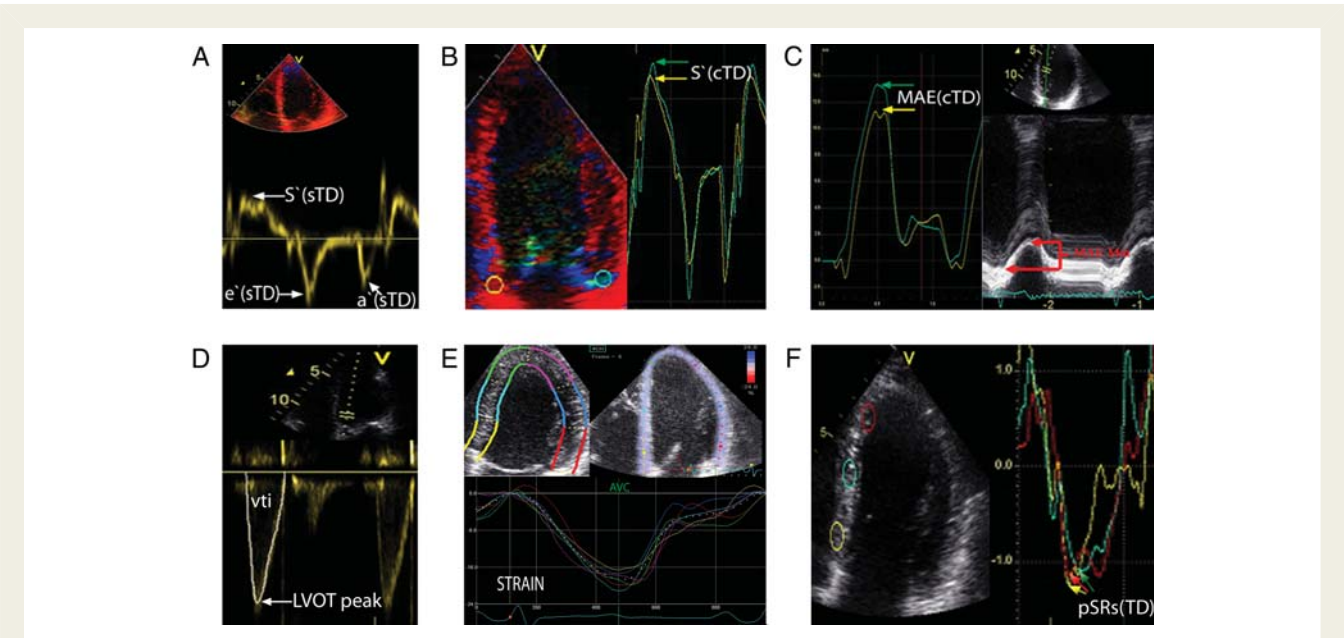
Representative measurements of left ventricular systolic performance obtained by different methods. (A) Spectral tissue Doppler (sTD)-derived septal mitral annulus velocities. Peak systolic velocity $S'(sTD)$, early diastolic velocity $e'(sTD)$, and late diastolic velocity $a'(sTD)$ measured at the maximum of the Doppler spectrum with a low gain setting. (B) Velocity curves from colour tissue Doppler (cTD). Peak systolic mitral annulus velocity $S'(cTD)$ measured at the peaks. (C) Measurements of systolic mitral annular excursion (MAE) by integrated velocity curves from colour tissue Doppler MAE (cTD) and by reconstructed M-mode MAE (Mm). (D) The left ventricular outflow tract (LVOT) peak velocity and velocity time integral (vti) measured by tracing the modal velocity. (E) Deformation indices obtained from two-dimensional speckle-tracking echocardiography with regions of interest and the corresponding traces of longitudinal strain. (F) Longitudinal peak systolic strain rate obtained from colour tissue Doppler recordings SR_s (TD).
